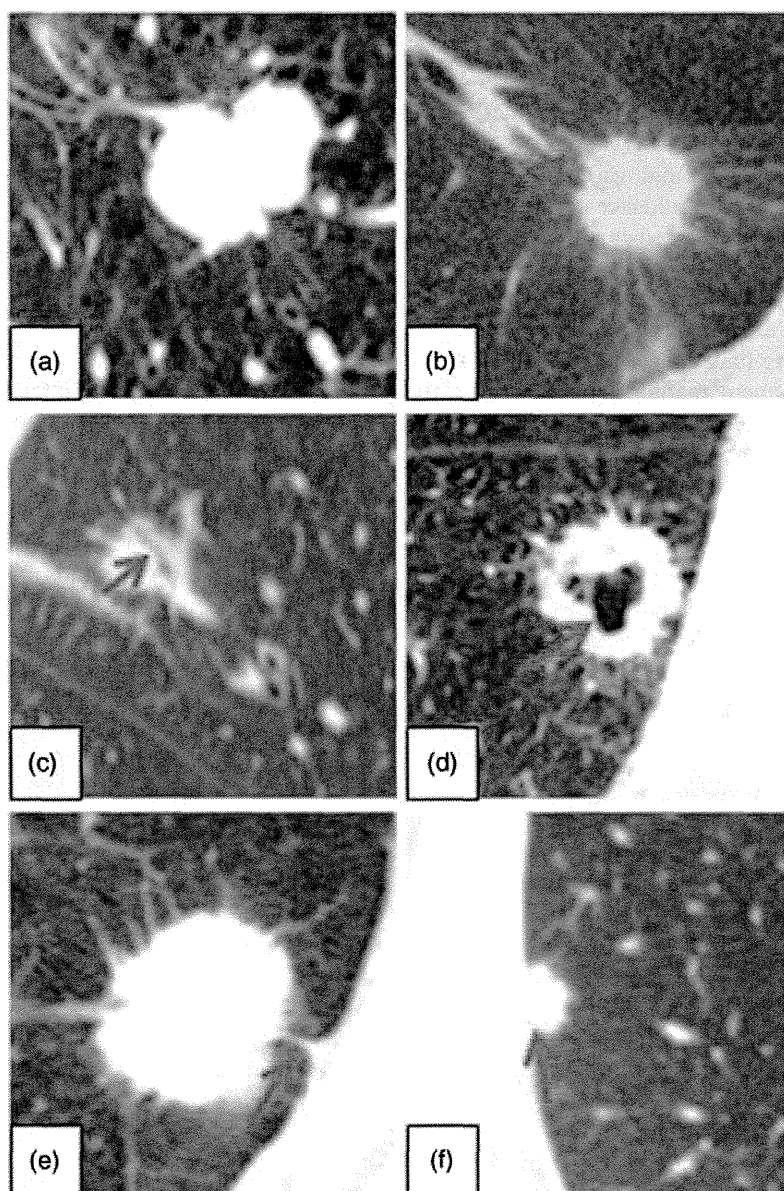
Thin-section CT findings. (a) Lobulation; (b) coarse spiculation; (c) air bronchogram; (d) cavity; (e) pleural tag; (f) pleural-based lesion.
